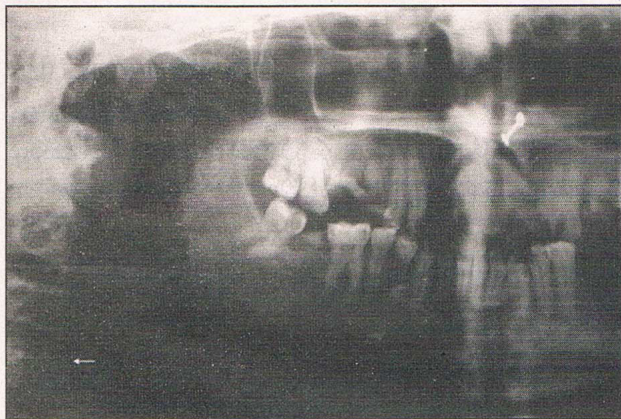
Panoramic radiograph showing a small radiopacity in the vertebral column in region of fourth cervical vertebra (arrow).
